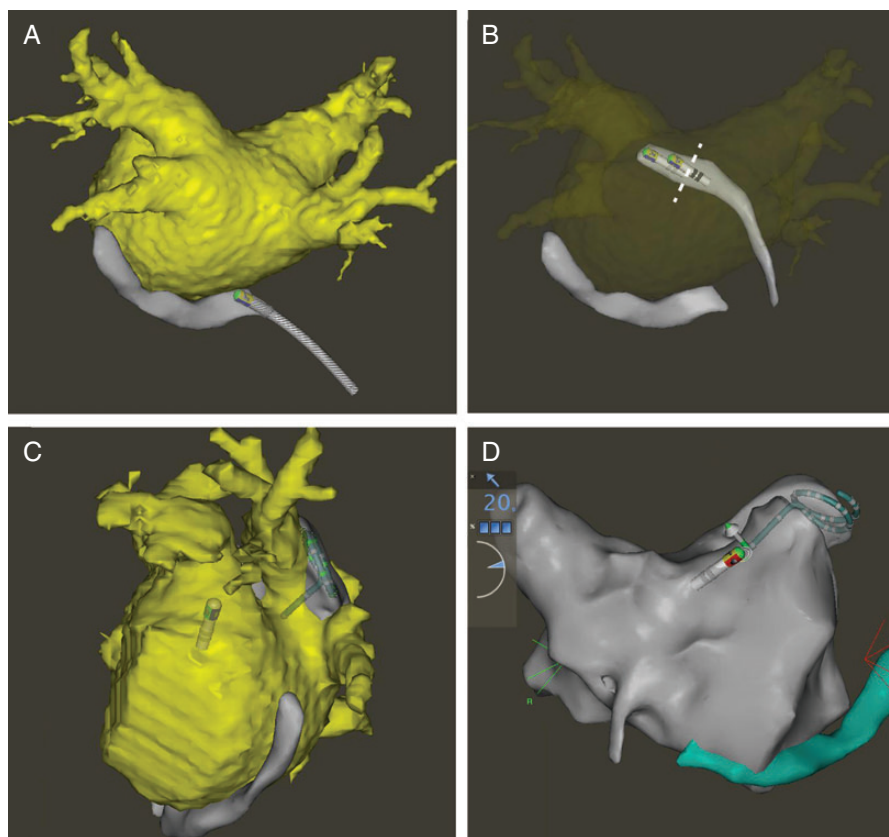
Images of the process and the features used for fluoroscopy-free mapping and ablation of the left atrium: (A) posterior view of the FAM of the coronary sinus (grey) with the manually registered anatomical reconstruction of the left atrium from MRI (yellow), (B) same posterior view as in (A) with the FAM of the transseptal puncture: the transition between the black and the grey visualization of the two proximal ring electrodes of the mapping catheter marks the exit of the catheter from the sheath and consequently the end of the sheath (dashed line), (C) Left lateral view of the left atrium with the Lasso catheter in the left superior pulmonary vein, (D) Contact force vector and the two-ring catheter projection as representation of the distance of the catheter tip from the closest FAM surface. The closer the catheter is to the surface, the smaller is the difference of the diameter of the two white rings projected on the grey surface.
